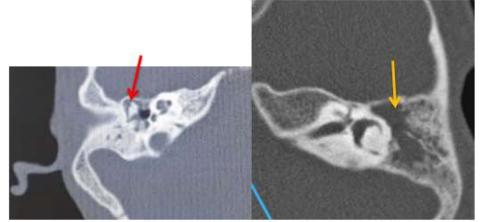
Axial CT images depicting soft tissue attenuation contents in middle ear cavity (red arrow), mastoid antrum (yellow arrow) and mastoid air cells
